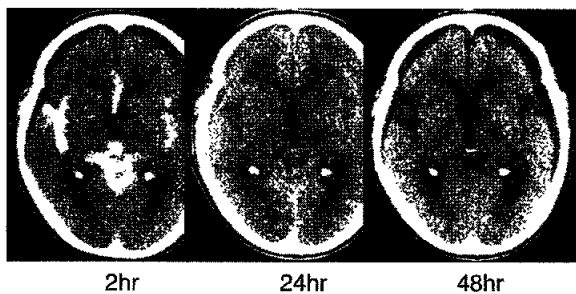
CT-cisternography. 3 serial views, 2, 24, and 48 hrs after intrathecal injection of contrast material (Isovist). The absence of washout delay or contrast material reflex in delayed phase at 48 hrs excluded possible iNPH. Incidentally, a CT scan revealed hygroma and shrinkage of ventricles (a form of external hydrocephalus) and a possible mechanism for this is described in text
